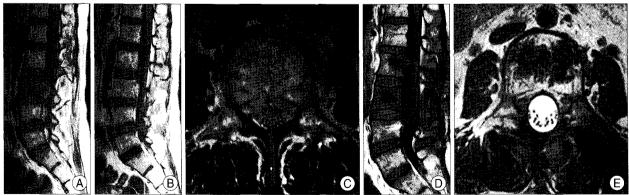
Pre-and post-operative magnetic resonance images. The preoperative magnetic resonance images of the lumbar spine showing low signal intensity on T1WI (A) and focal enhancement on T1C+ (T1-weighted image enhanced) (B), and a lesion affecting the entire L3 vertebral body with the pedicle and extending to the epidural space in a curtain shape (C). The postoperative magnetic resonance images showing a significantly decreased epidural lesion compared with the preoperative images (D and E).
